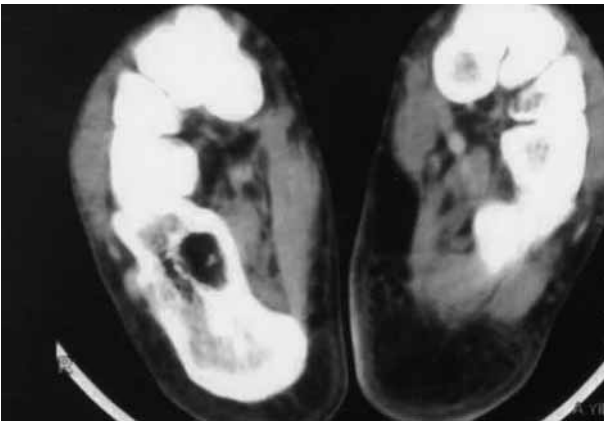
Axial CT-scan : typical of adipose tissue
